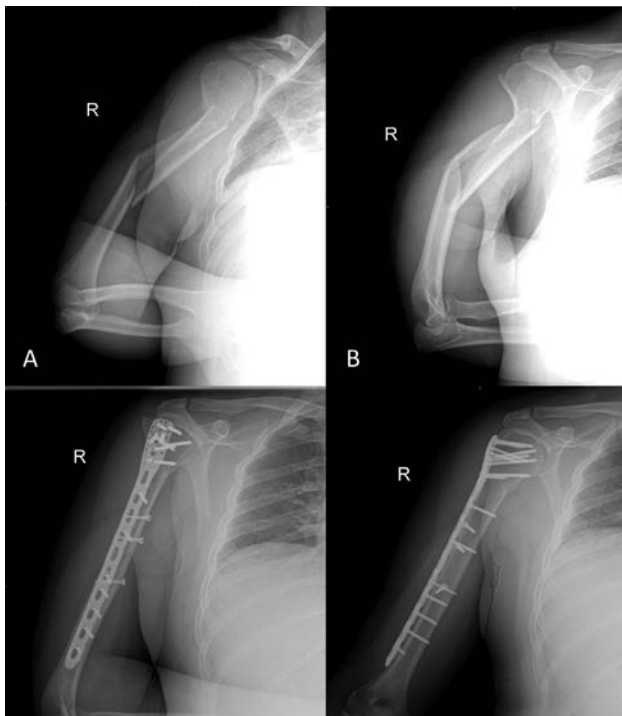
(A and B) Anteroposterior and oblique shoulder radiographs that depict a proximal humerus fracture with a segmented diaphyseal extension. The patient is treated with a long proximal humeral locking plate with multiple interfragmentary screws.
